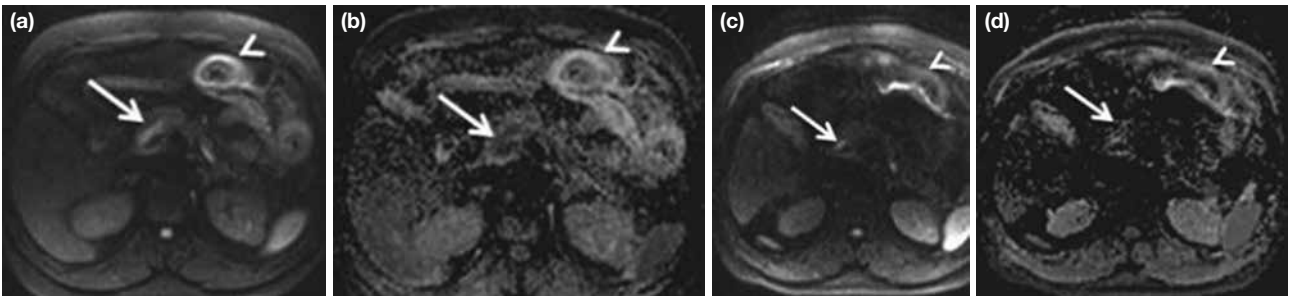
a–d. A 43-year-old man presenting with abdominal pain, nausea and vomiting. The small bowel ischemia and acute portal vein-superior mesenteric vein thrombus (arrow) shows high signal intensity on axial diffusion-weighted MR image and corresponding low signal intensity on ADC map at presentation (a, b). On follow-up axial diffusion-weighted MR images after medical treatment, lysis of portal vein-superior vein thrombus and healing of bowel wall (arrow head) is seen (c, d).
